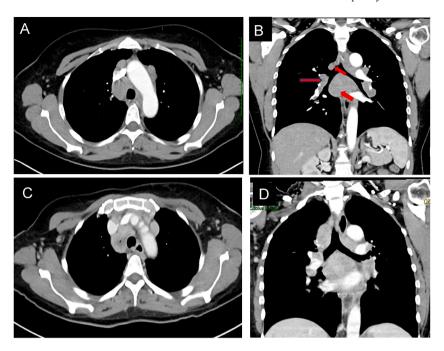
(A) February 3, 2020 Chest X-Ray: Mediastinal and hilar lymphadenopathy. (B) April 17, 2020 Chest X-Ray: Reduction in the size of lymphadenopathy. (C) January 6, 2022 Chest X-Ray: Further reduction in the size of lymphadenopathy.
